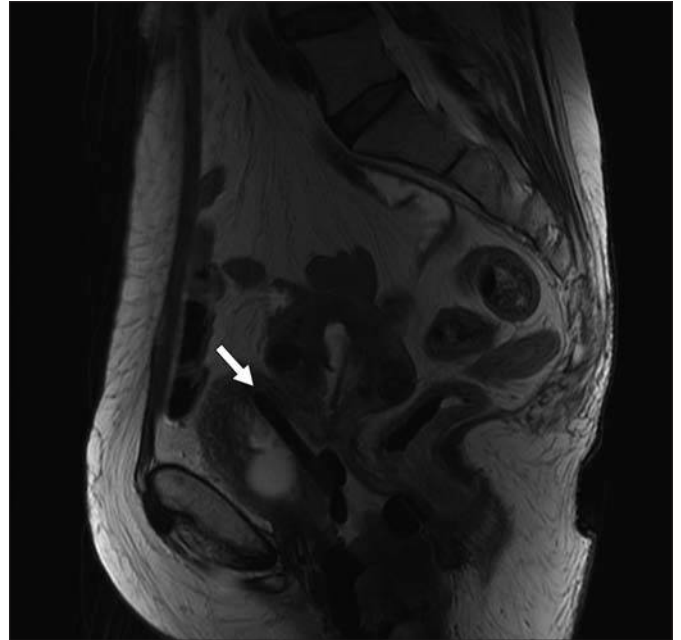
58-year-old woman with cervical cancer. Sagittal T2-weighted MR image shows intracavitary brachytherapy probe (*arrow*) has perforated anterior wall of vagina and is positioned within bladder, creating traumatic fistula. Fistula healed spontaneously without significant complication.
